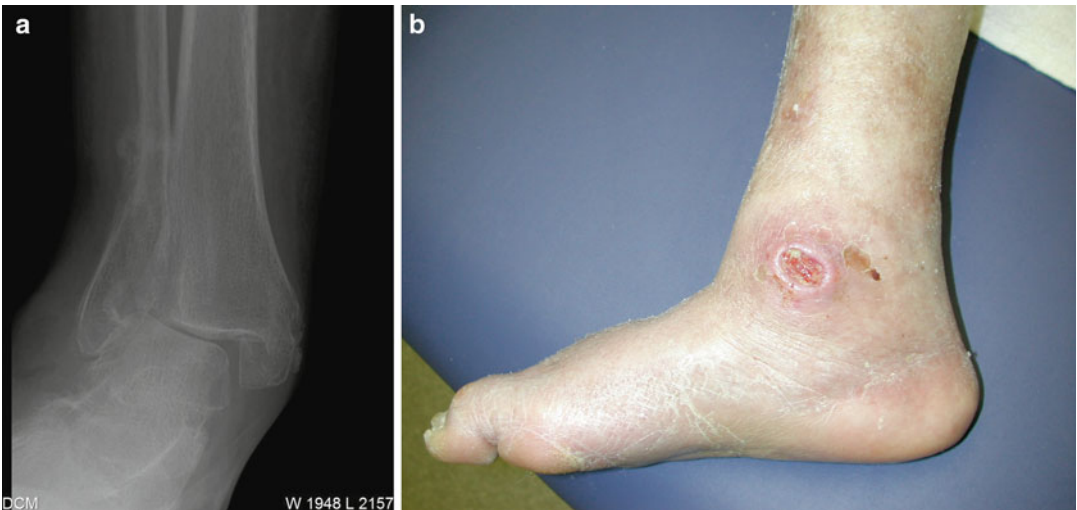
Findings in Brodsky type 3A Charcot arthropathy (a) Anteroposterior (AP) radiograph obtained almost one year after presentation shows a severe valgus deformity (b) Associated ulceration over the medial malleolus
